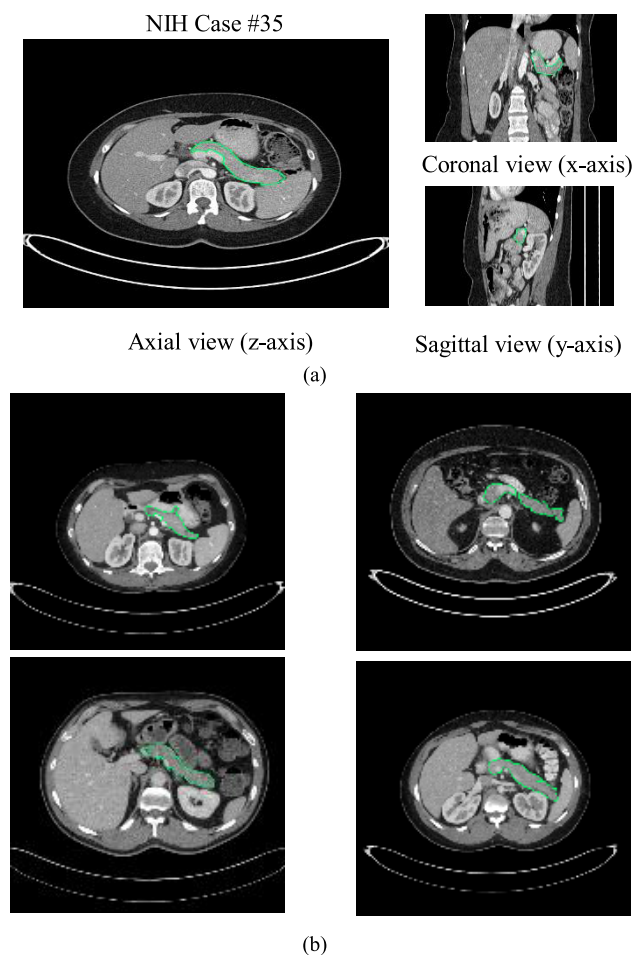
(a) The position of the pancreas is marked in green in the CT three different viewpoints. This is a small organ. (b) The pancreas is marked in green. It is an organ with an irregular shape and boundary.
